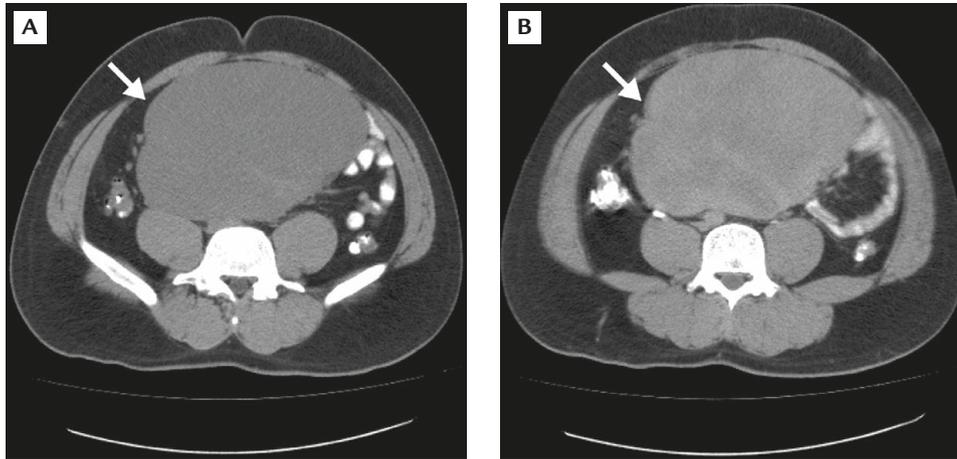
(A) Non-contrast abdominal computed tomography revealed a huge homogeneous mass lesion (arrow) with a well-defined margin in the midline abdomen and deviation of the bowel loops laterally. No inner calcification could be identified. (B) After contrast media administration, the mass (arrow) showed mild enhancement, mainly in the periphery. No vascular structure in the mass could be identified.
